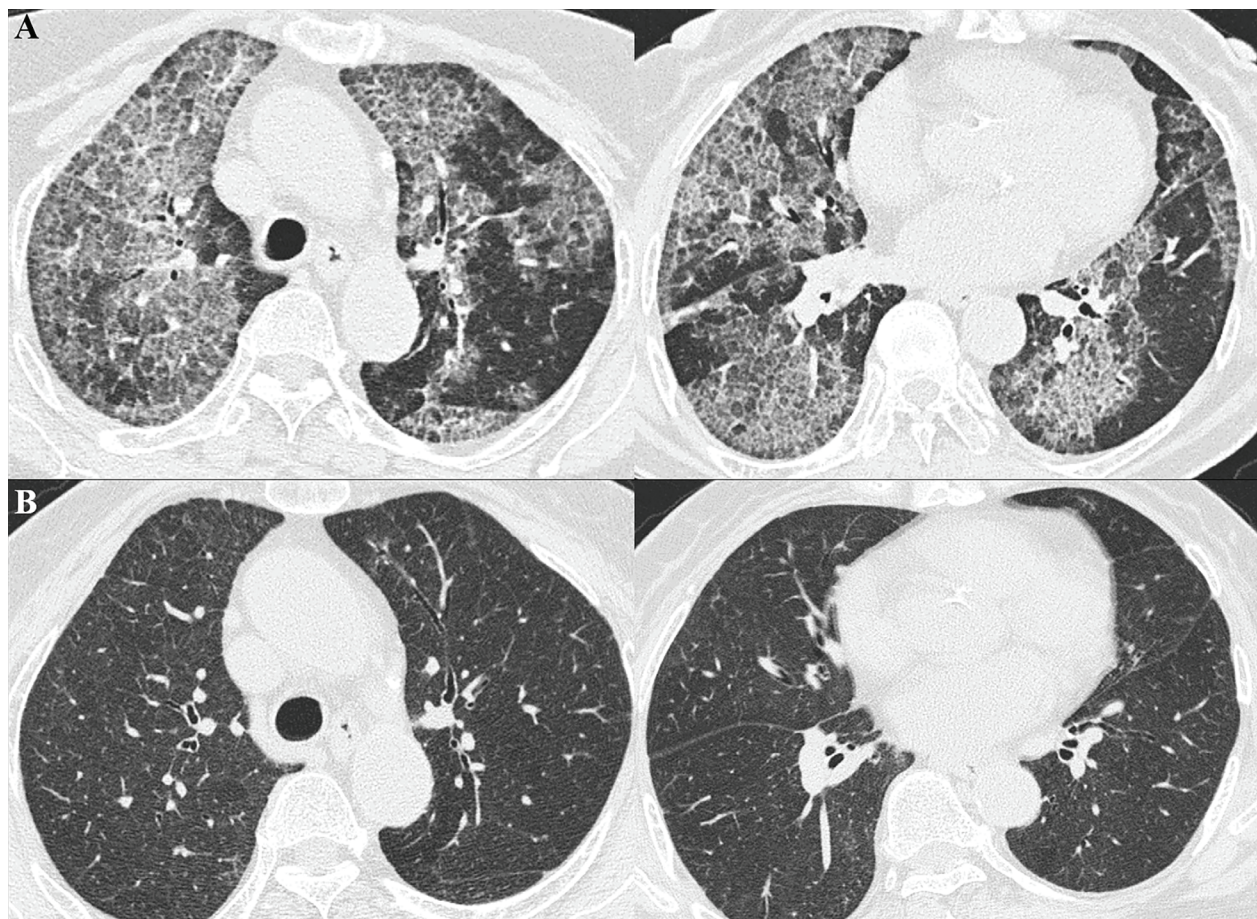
(A) Chest CT in November 2020, revealed bilateral ground glass opacity and crazy paving. (B) Chest CT in May 2021, revealed total remission of the lesions found previously.
